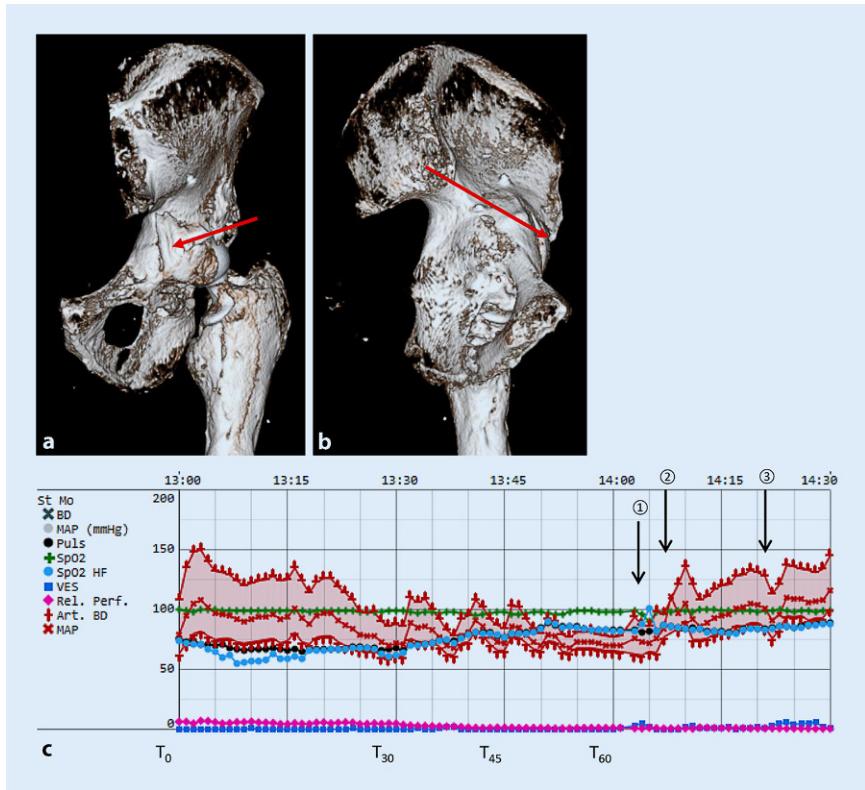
▲ a, b Reconstruction of the preoperative computed tomography scan of the left hip, anterior-posterior and lateral view. Calcifications of the bursa ilipectinea marked by arrows. c Excerpt of the hemodynamic parameters of the electronic anesthesia protocol. T₀ to T₆₀ surgery (in min). Arrow 1 supine position and transesophageal echocardiography, arrow 2 left tilt, arrow 3 abdominal sonography and paracentesis. BD blood pressure, MAP mean arterial pressure, SpO₂ percutaneous oxygen saturation, HF heart rate, VES ventricular extrasystole, Art. BD invasive arterial blood pressure
